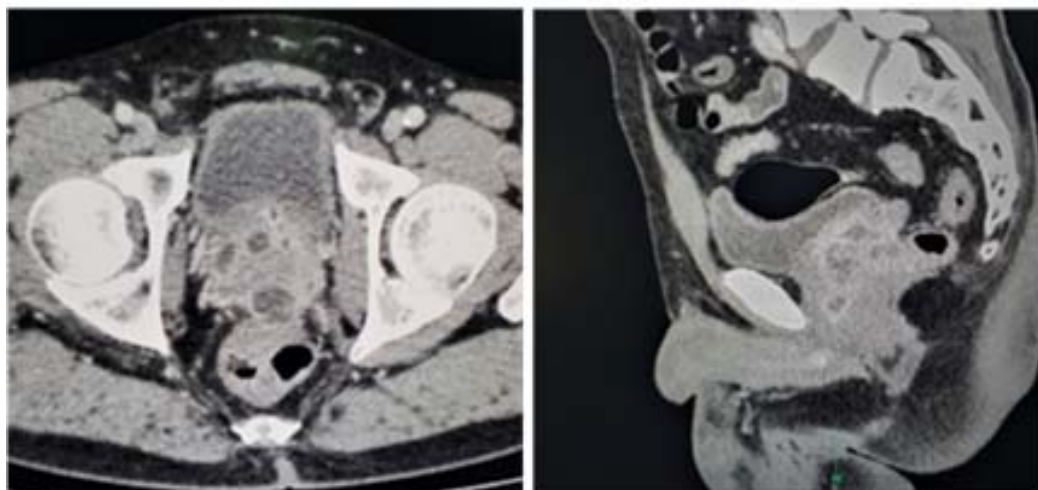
Axial and sagittal CT images demonstrating multifocal prostatic abscesses.
